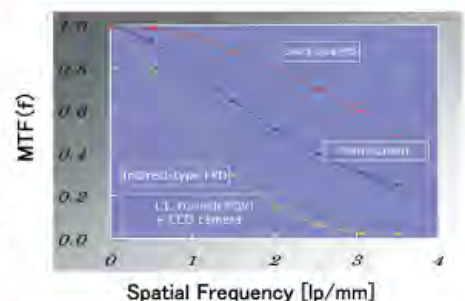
Comparison of MTF Curve for Different X-ray Detectors
